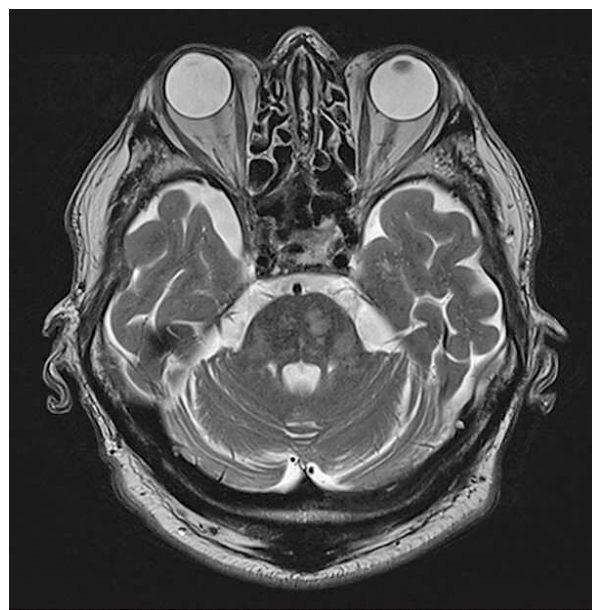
Axial T2WI MRI shows multiple punctate and patchy regions in the pons and cerebellar peduncles.
